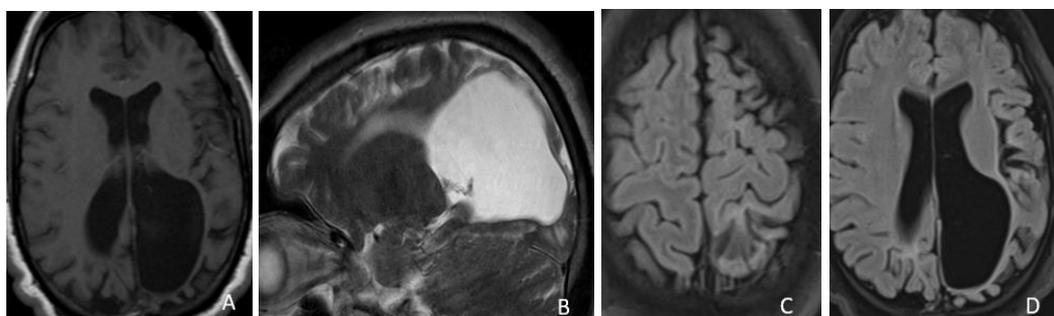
axials T1 (A), FLAIR (C, D) and coronal T2 weighted magnetic imaging showing -Bilateral polymicrogyria involving more marked in the occipital lobe associated with colpocephaly. -Hyperintensity and left frontoparietal cortical dysplasia.
